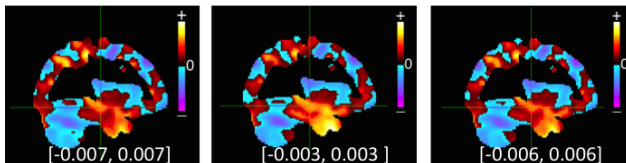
This figure shows a sagittal slice through the weight vectors for the structural MRI dataset, with the weight range given in brackets (a) Image data only, (b) Image data adjusted by all NV, (c) Image data and all NV
